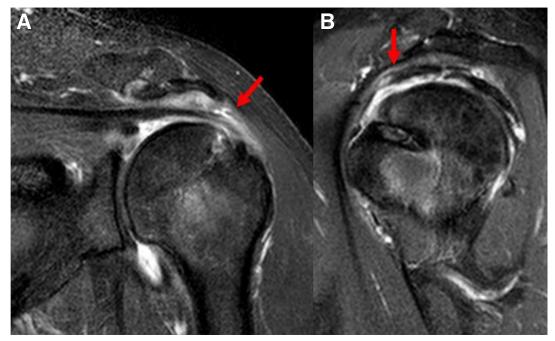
Preoperative MRI finding (A and B) oblique and coronal MRI view of retorn high-grade partial articular supraspinatus tendon avulsion (PASTA) lesions.
